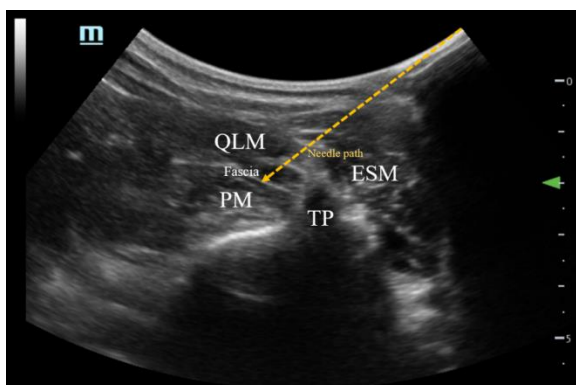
Quadratus Lumborum Block using the Ultrasound-Guided: The Needle Path to the Musculofascial Plane Between the Quadratus Lumborum Muscle and Psoas Major Muscl.e*
